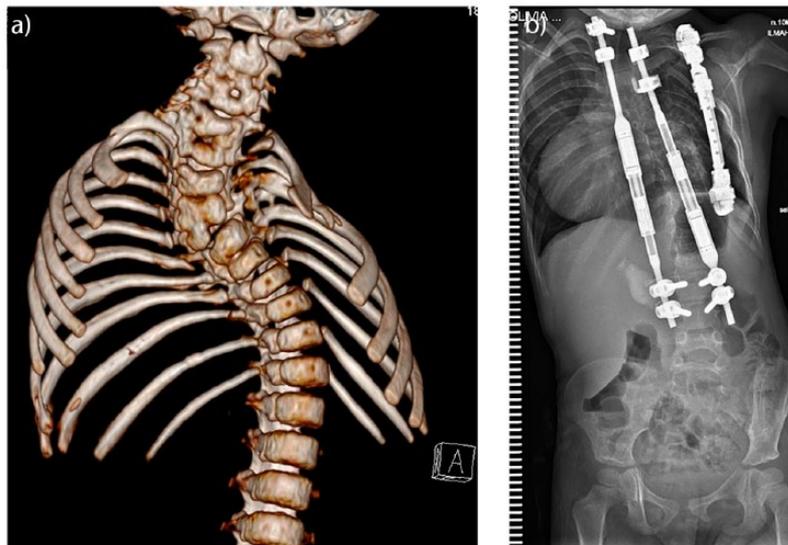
a) 3D CT format demonstrating congenital scoliosis with fused ribs (spondylocostal dysostosis) at the age of one year; b) three-year postoperative standing radiograph after staged thoracostomy and rib-to-rib vertical titanium prosthetic rib instrumentation (at the age of one year) and magnetically controlled growing rod surgery at the age of 1.5 years.
